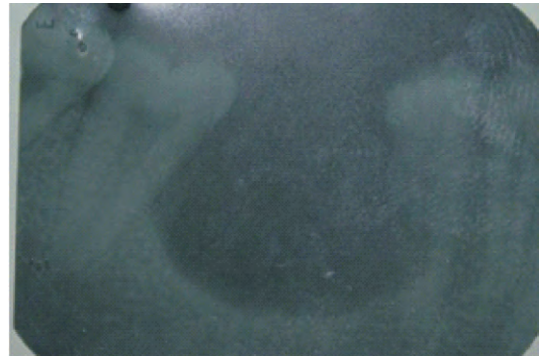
Intra Oral Periapical Radiograph
